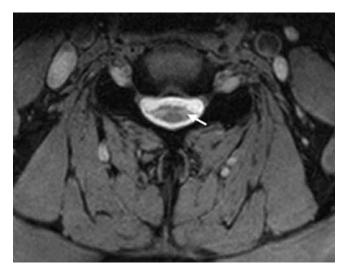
Patient with Multiple Sclerosis. Hyperintense, wedge-shaped, peripherally located lesions (arrow) were observed on axial T2-weighted MR image at the C4 level. These cord lesions occupyied less than half the crosssectional area of the cord.
